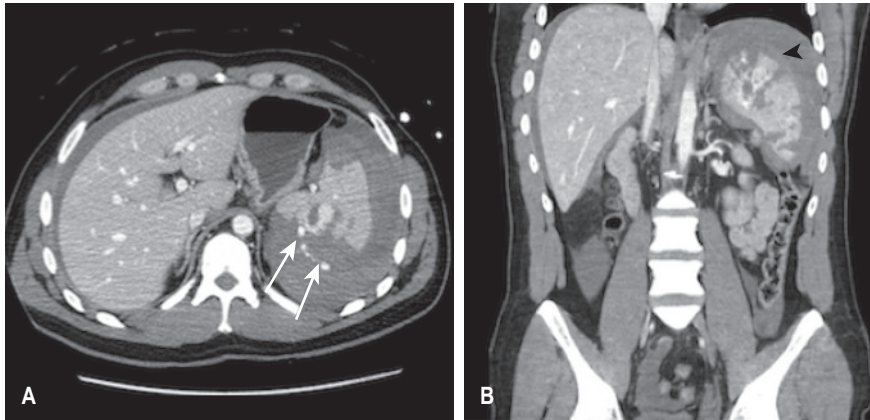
Axial (A) and Coronal (B) Computed Tomography images of the abdomen demonstrating a shattered spleen with active bleeding (white arrows) and a large Grade 5 splenic haematoma (black arrow head)".
